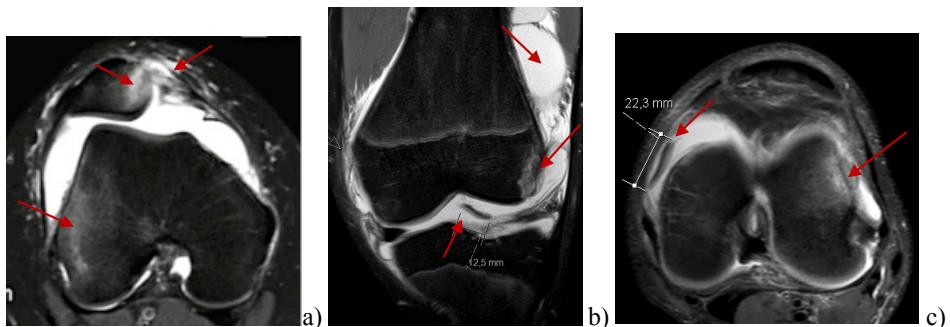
Typical signs of lateral patellar dislocation observed by MRI (proton density weighted imaging with fat saturation). (a) Axial view shows bone bruising (edema) on the medial patella and lateral femoral condyle, MPFL injury at the patellar site, and hemarthrosis (b) Coronal view shows osteochondral fragment, a lateral femoral bone bruise (edema), and hemarthrosis. (c) Axial view shows an osteochondral fragment, a lateral femoral bone bruise (edema) and a defect, and hemarthrosis.
